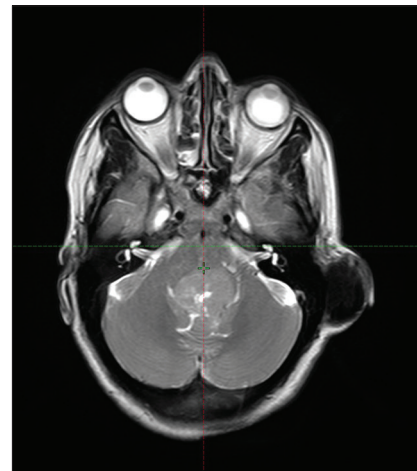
Magnetic resonance imaging T1 axial image showing the lesion of size 3.5 cm \times 3 cm \times 4.5 cm in the midline posterior fossa in relation to the fourth ventricle
